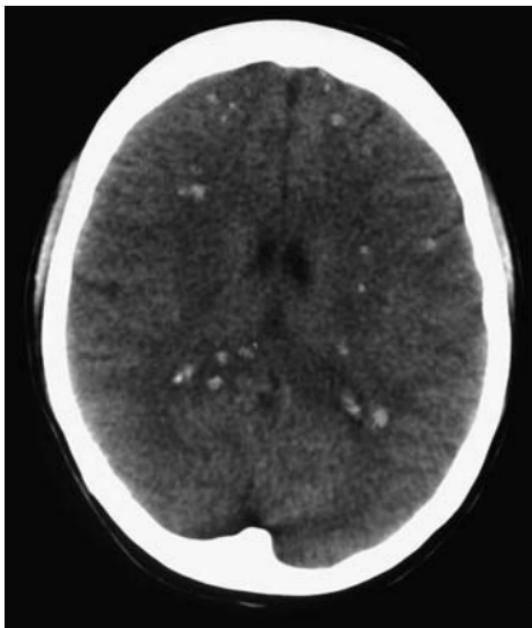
Diffuse axonal injury (DAI; non-enhanced CT). Severe shear-strain injury resulting in multiple foci of acute petechial haemorrhage involving the splenium and posterior aspects of the corpus callosum and frontal parenchyma predominantly at the grey-white matter interface.
